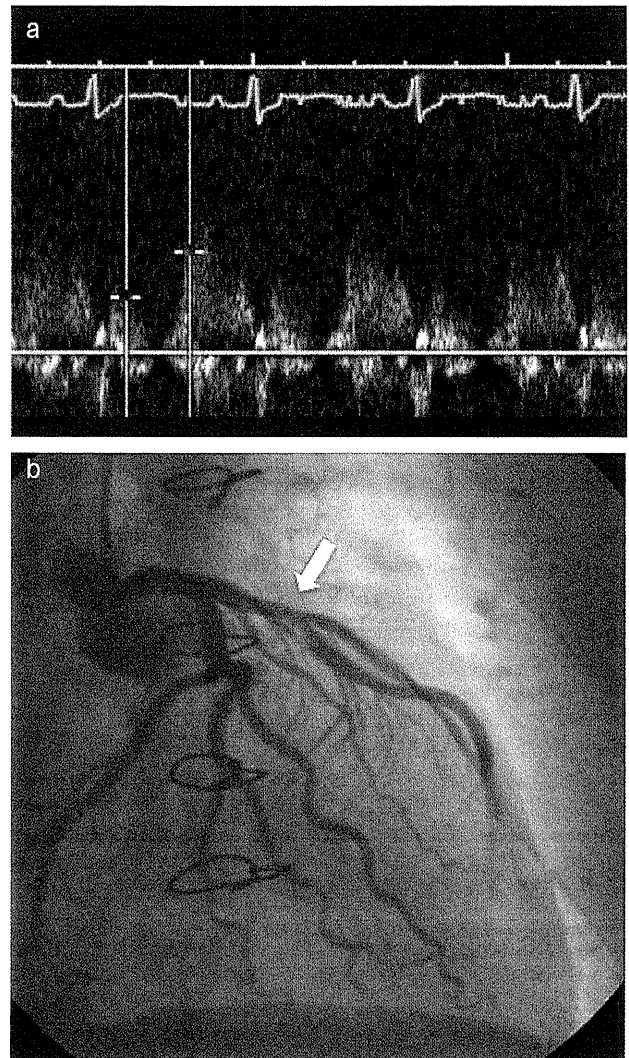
Representative recording of Doppler flow imaging of distal left anterior descending coronary artery (a) obtained from a donor heart with risk factors for ischemic heart disease, and the first angiogram of the recipient who received the heart which was performed in the month after transplant surgery (b). The arrow indicates about 50% narrowing of left anterior descending coronary artery.
